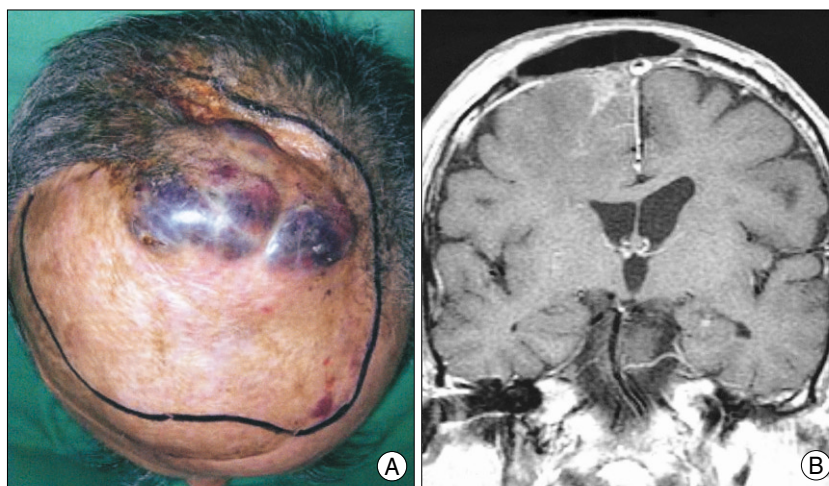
A : Photograph shows scalp bulging with accompanying necrosis in the previous operative area. B : Enhanced coronal T1-weighted magnetic resonance image shows slightly enhancing lesion on the parasagittal area adjacent to the previous operative field.
